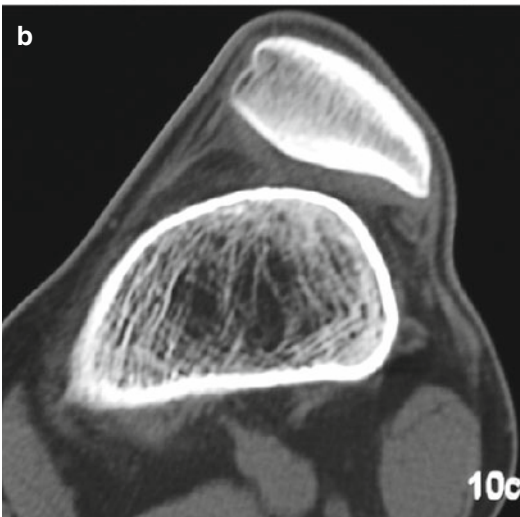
(a) Axial CT scans with flat trochlea and lateralization of the patella (*in extension*). (b) Increased lateral subluxation of the patella with muscle contraction (same patient as in Fig. 32.10a)
